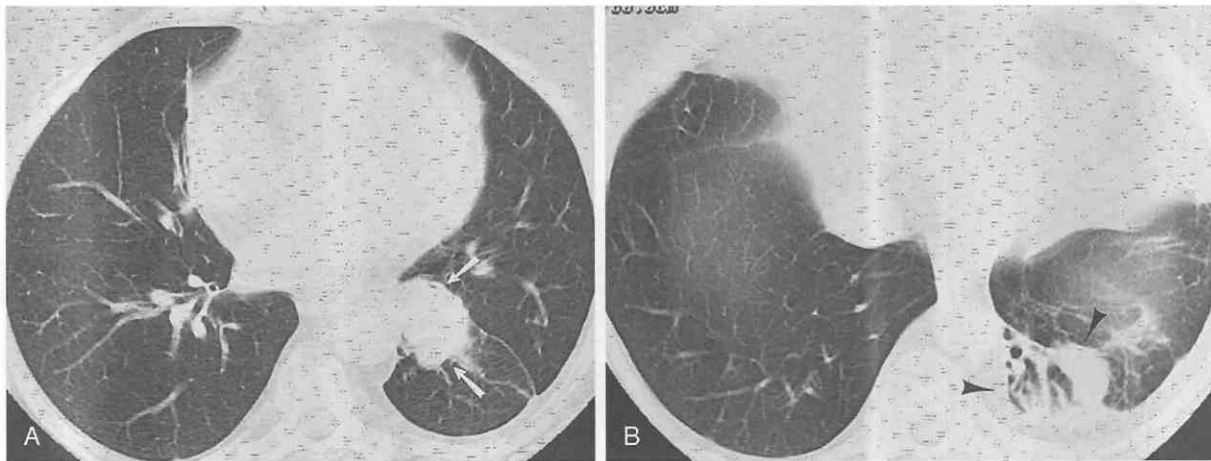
Typical carcinoid tumor manifesting as recurrent pulmonary infections. *A* and *B*, CT shows a mass in the segmental bronchus of the left lower lobe (arrows in *A*), left lower lobe volume loss, and distal bronchiectasis in the atelectatic lung (arrowheads in *B*).
